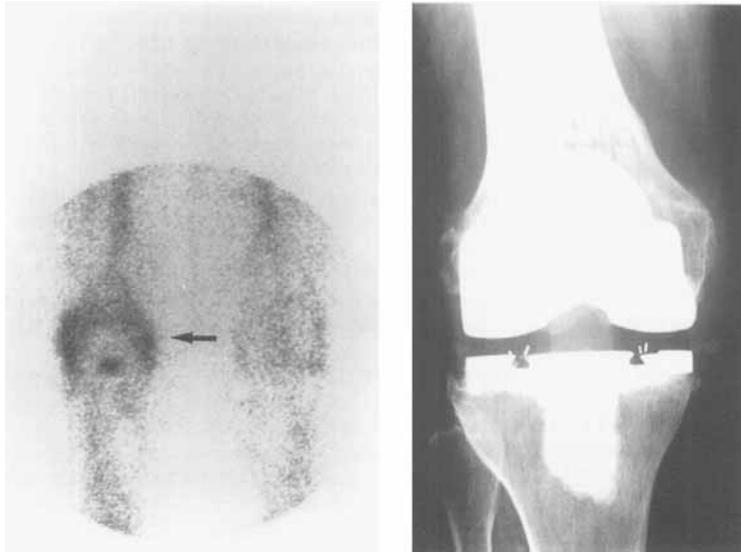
In-111-IgG scintigraphy of 71-year-old woman with a painful swollen right knee, 1 year after total knee arthroplasty. Puncture showed no infection. The focal accumulation of In-111-IgG (arrow) was seen to be located in soft tissues around the arthroplasty and probably caused by aseptic inflammation of soft tissues. Nevertheless, the scintigram was interpreted as false-positive for infection. No radiolucency, only some ossifications laterally in the soft tissues.
